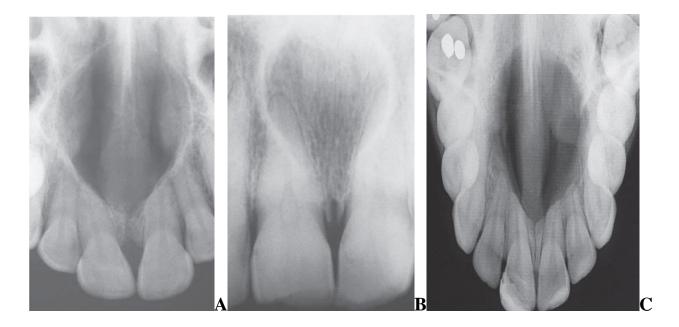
A- Nasopalatine duct cyst. Large destructive cyst of the palate. B-Large destructive cyst of the palate. B-Nasopalatine duct cyst. Well-circumscribed radiolucency between and apical to the roots of the maxillary central incisors. (Neville et al, 2009) C-Maxillary occlusal radiography showing well-defined unilocular radiolucent image in maxillary anterior region. (Leandro et al,2017)
